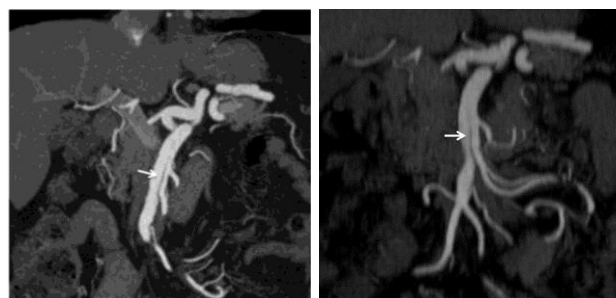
A 64-year-old man was admitted to the hospital with abdominal pain. On coronal maximum intensity projection (MIP) reconstruction CTA scan (a), an isolated SMA (Type IIa) dissection is observed (arrow). Follow up CTA (b) was performed 8 months later, which showed no progression in dissection (arrow).
